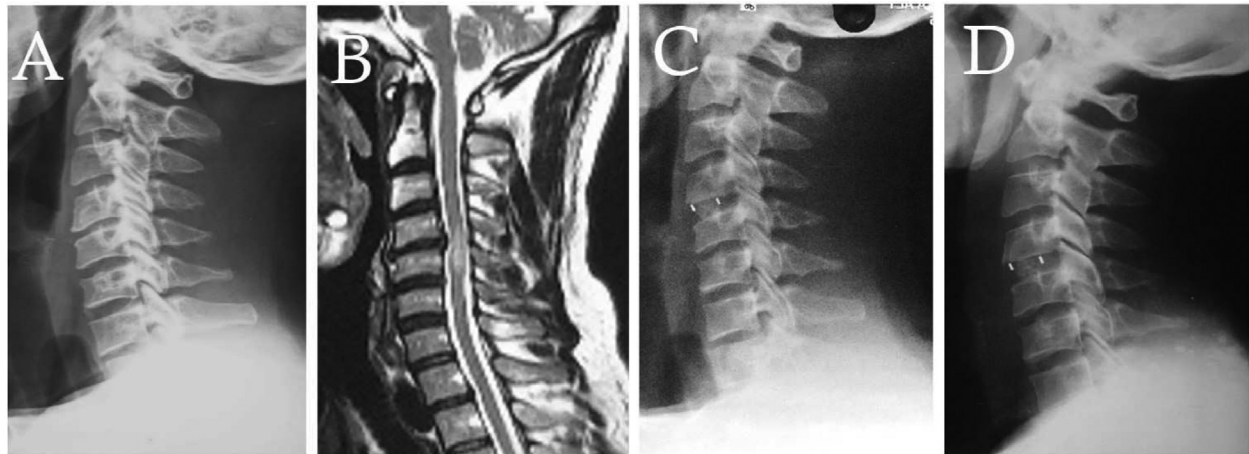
(A) Preoperative lateral plain radiograph of a 49-year-old female patient with cervical myelopathy. (B) Preoperative sagittal T2 MRI showing C4–C5 discostenotic lesion. (C) Three-month postoperative lateral radiograph. (D) Six-month postoperative lateral radiograph showing good cage position and alignment.
